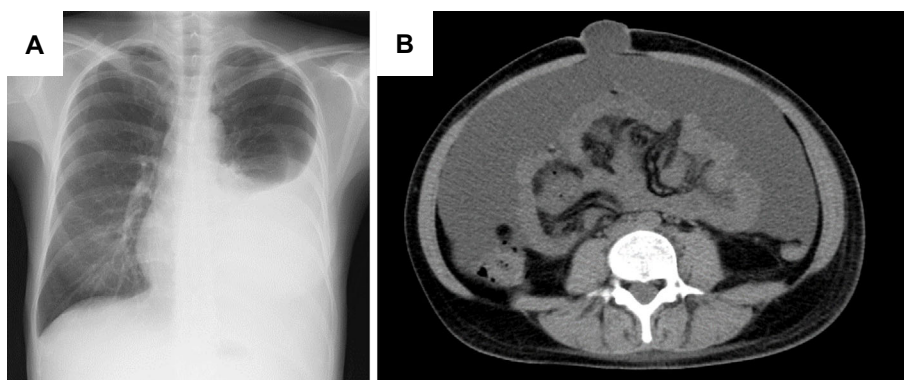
(A) Chest radiograph in February 2016 showed massive left-sided pleural effusion, and (B) abdominal CT showed massive ascites and the protruding navel.
